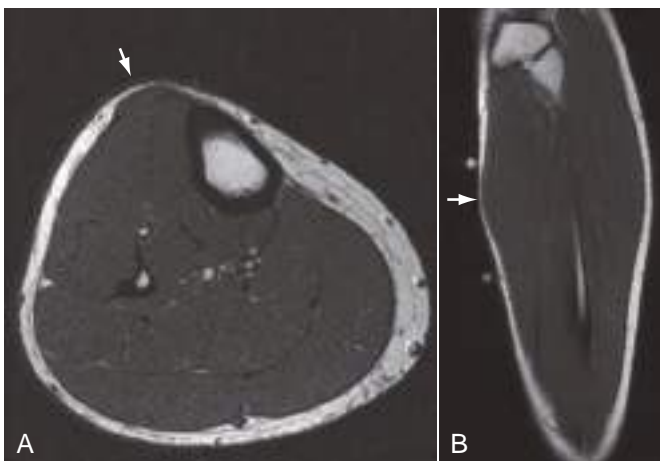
Myofascial defect. Axial (A) and coronal (B) T1-weighted MR images in a 25-year-old patient with a palpable lump in the anterior proximal right calf show subtle anterior muscle protrusion (arrows).
